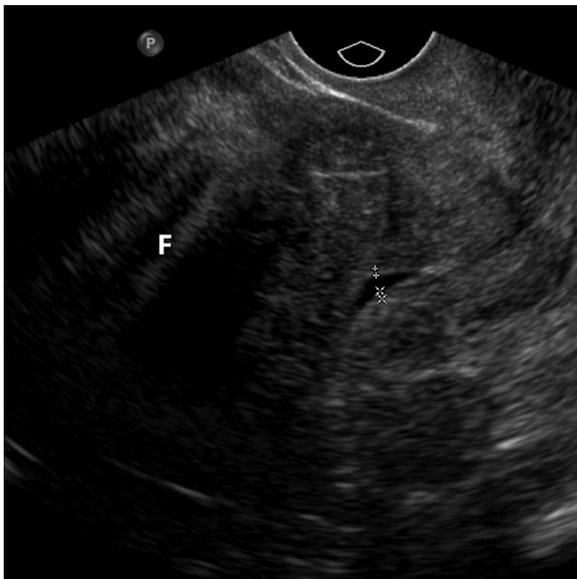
A 54-year-old postmenopausal woman with history of fibroids. Transvaginal sagittal ultrasound shows a small amount of fluid in the endometrial canal. The 2 layers of echogenic endometrium are added together to give an endometrial thickness of 4 mm that is normal (calipers). There is a shadowing fibroid at the uterine fundus that is difficult to measure with ultrasound (F).
